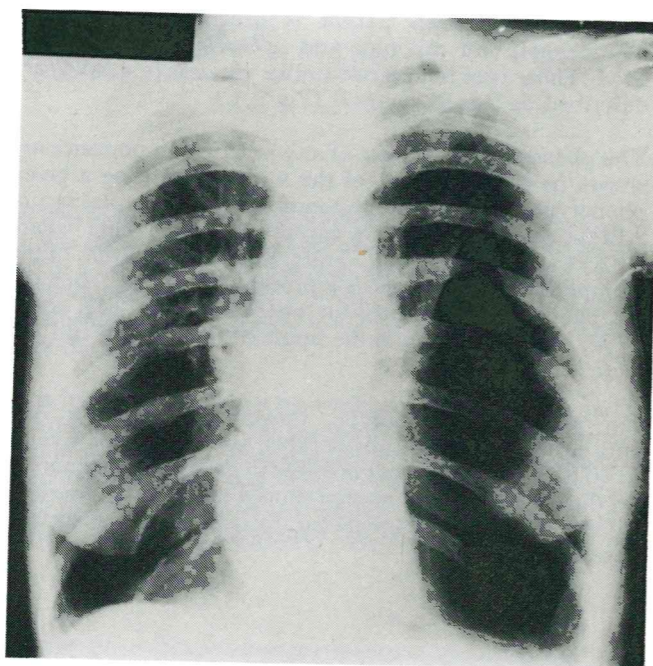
Chest radiograph of a woman of 55 years (Type ZZ) showing a large bulla in the left lower zone, causing mediastinal shift (Lung function tests in table 2).
